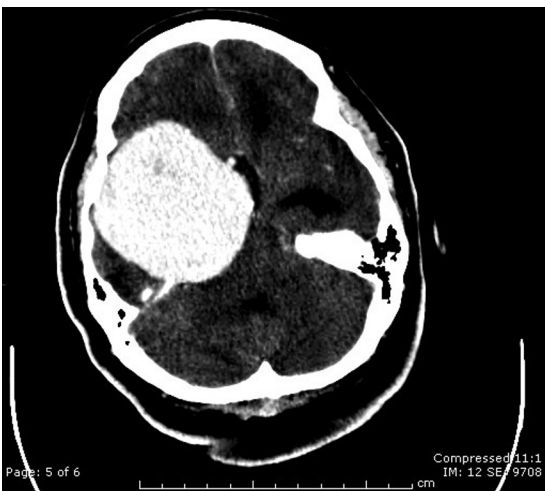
Post-contrast axial CT image demonstrates homogeneous enhancement.
